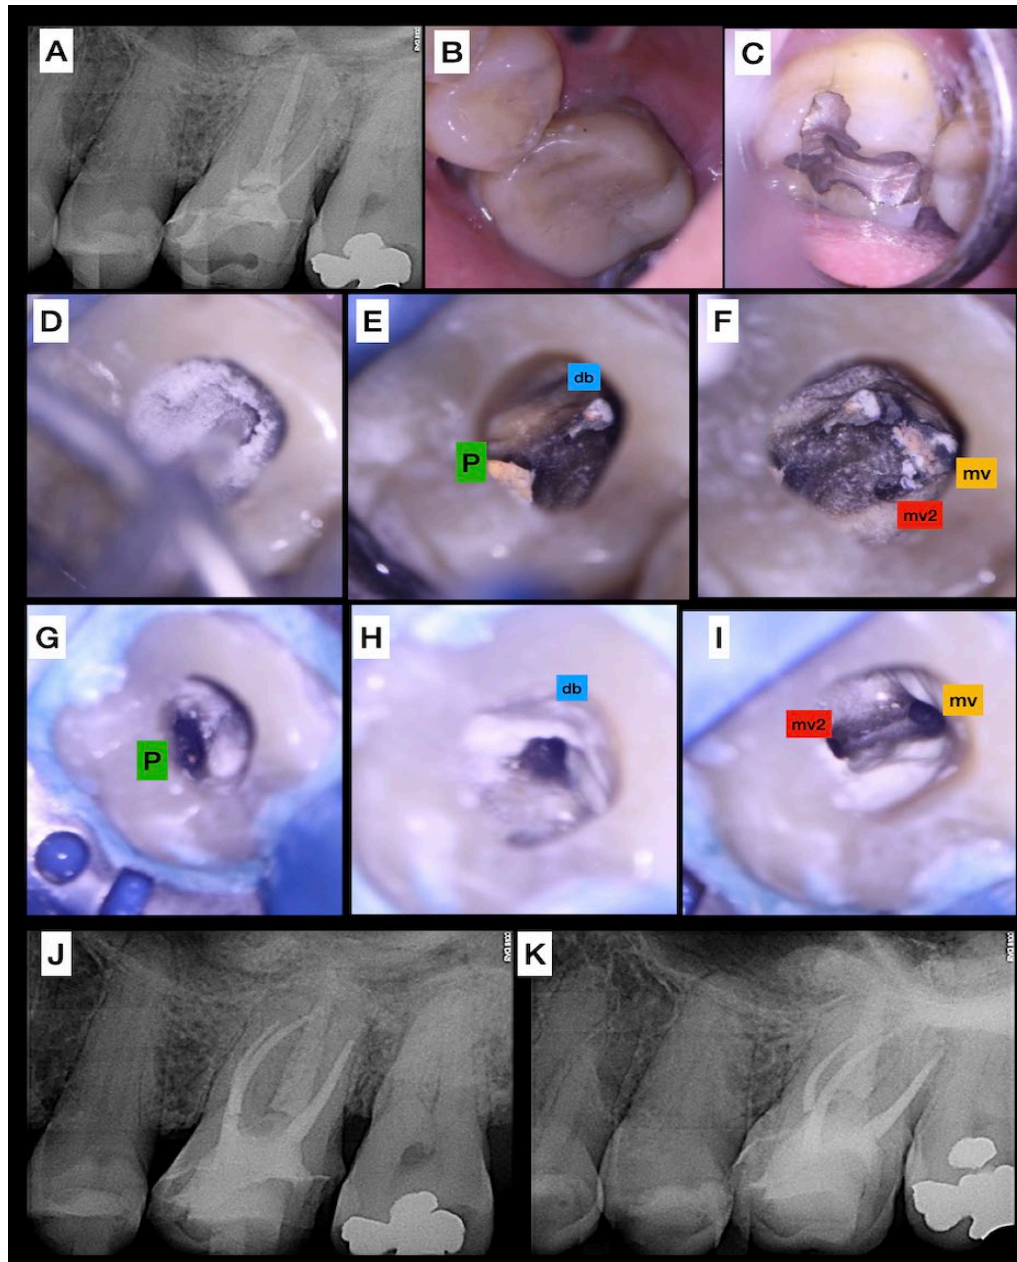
Treatment of case 1, A) Preoperative periapical radiograph; B, C) Preoperative clinical aspects of teeth #26 and #27; D) Ultrasonic tip cleaning the pulp chamber; E, F) the four root canals located; G, H, I) The four root canals cleaned; J, K) Immediate postoperative periapical radiographs; Abbreviations of root canals: mv, mesio-buccal 1; mv2, mesio-buccal 2; db, distobuccal; and P, palatal
